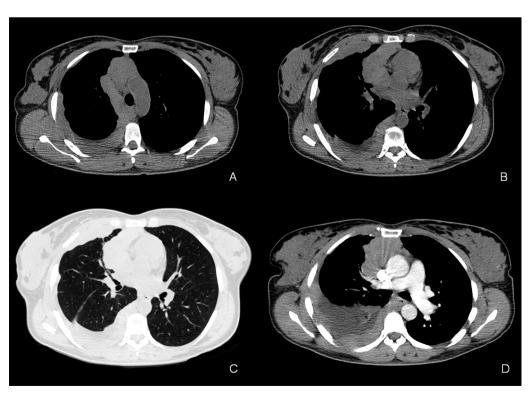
Chest Computed Tomography (CT) axial plane, on mediastinal windows, showing multiple masses in mediastinum and right pleura, with pleural free fluid, without displacement of mediastinal structures (A–B). No bronchial compression or atelectasis of lung is noted on lung window (C). After injection of iodinated contrast, the lesion appears hypo-vascular, with enhancing margins, internal lobulation and septation, and few calcific spots (D).
